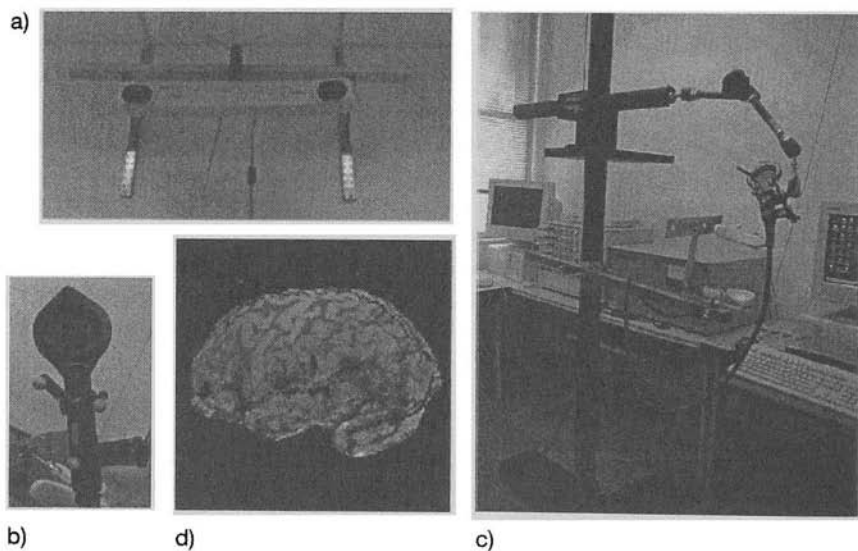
Frameless stereotactic system (Rogue Instruments): (a) Around the two cameras (Polaris) are two rings of emitters, (b) The LEDs reflect on the reflectors attached to the coil and the subject's head, (c) The subject's head rests on a head-coil stand (Bogen) and is coregistered onto their MR image, (d) Target (site of stimulation) can be identified according to their anatomy or functional data.
